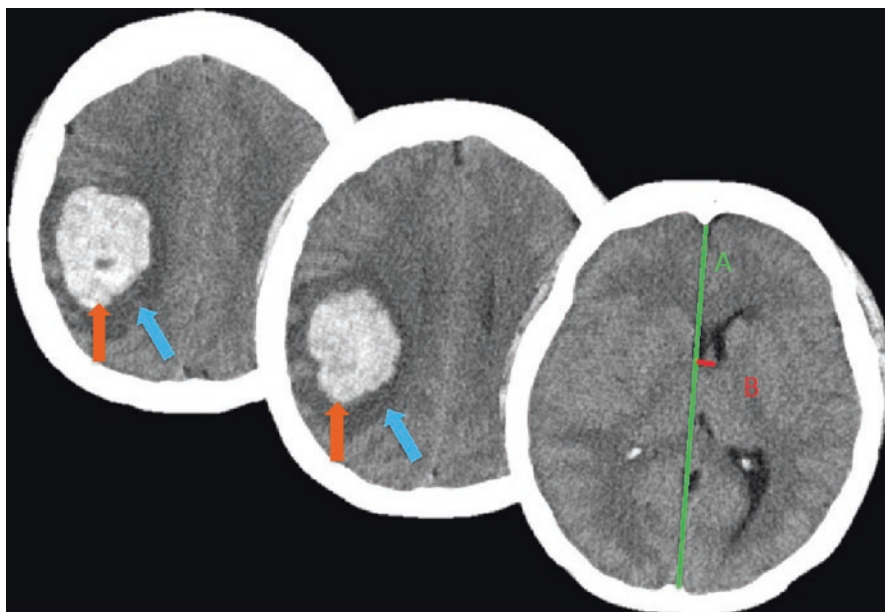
Relevant axial non-contrasted head CT images for Case 1 are shown. Left image and middle image characterize the hematoma. *Orange arrows* identify the hyper density, which is the acute hematoma. *Blue arrows* identify a hypo dense rim around the hematoma, which is perihematomal edema. Right image identifies how midline shift can be measured. *Green line* marked “A” represents midline. *Red line* marked “B” represents how far central structures (in this case the septum pellucidum) have been pushed from midline, hence midline shift. This measurement is typically expressed in millimeters
